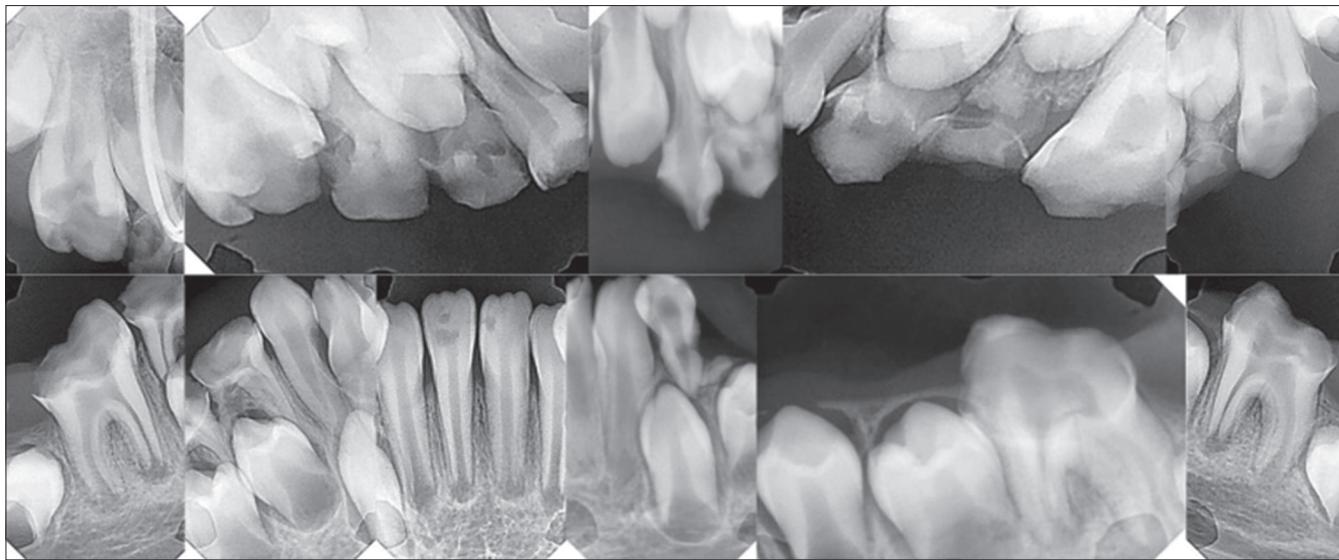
Full mouth periapical radiographs that are taken when the patient is under general anesthesia
